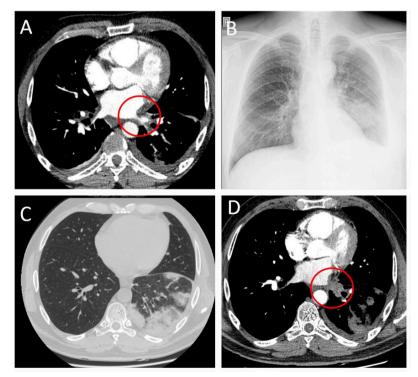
CT scan showing narrowing of the left lower PV (A); chest X-ray with patchy area in the left lower lobe (B); CT scan showing areas of patchy consolidation of the left lower lobe (C), and total occlusion of the left lower PV (D)
